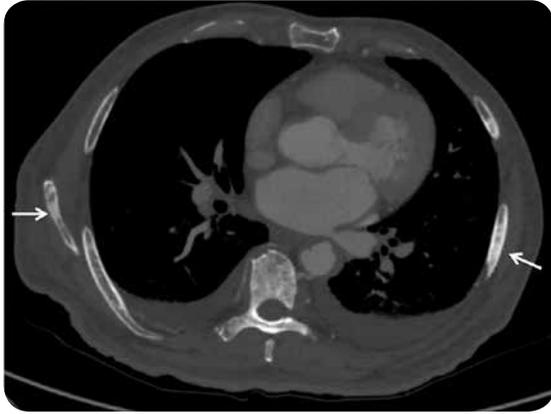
CT angiography, axial cut in bony window: Blast lesions (white arrows) are seen in the sacral arches secondary to prostate cancer.
